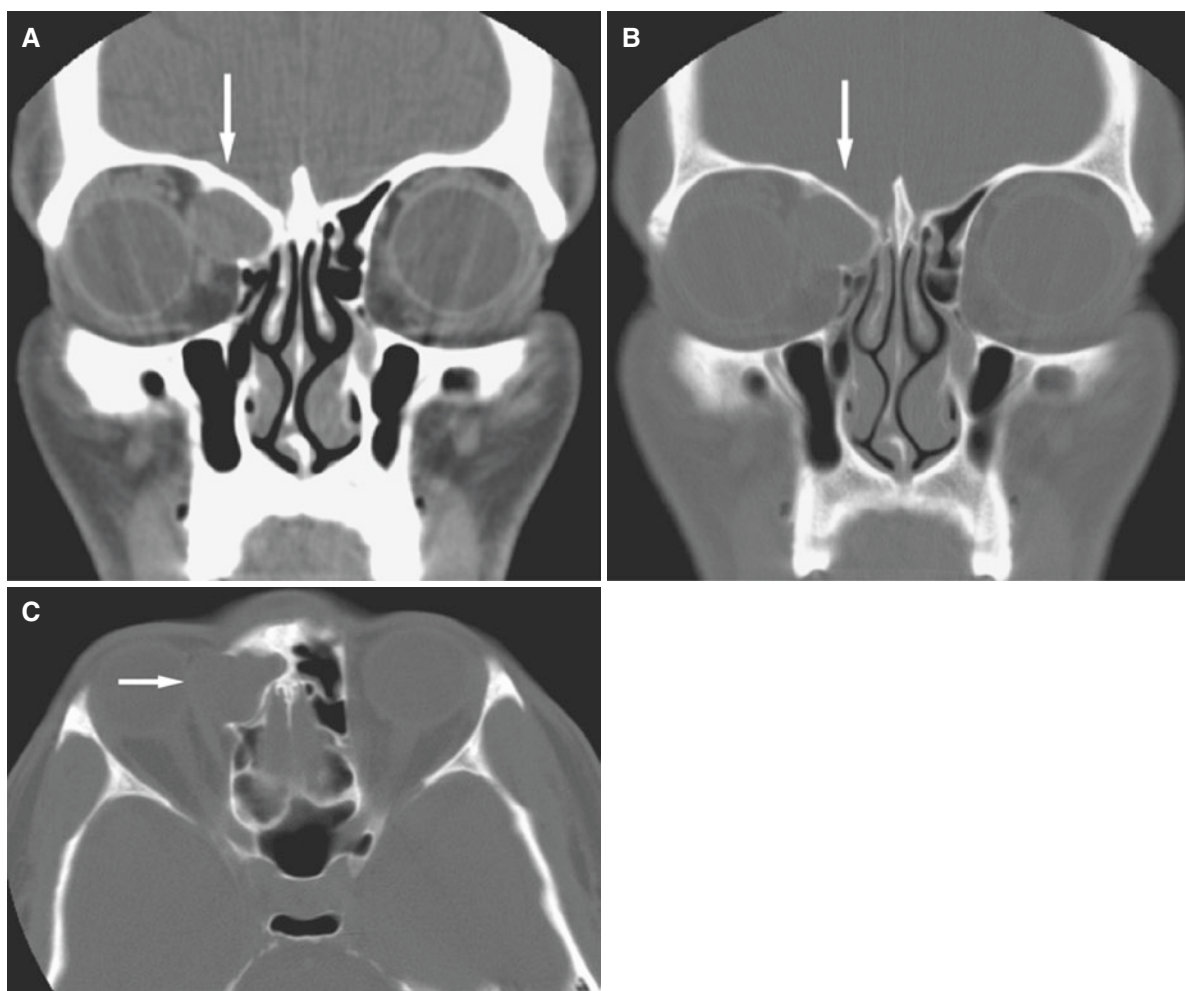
Frontal sinus mucocèle; 50-year-old male with diplopia and right eye down and laterally deviated. (A) Coronal CT image, soft-tissue window, shows ovoid well-defined soft-tissue mass in the right orbit (*arrow*) with displacement of globe laterally down. (B) Coronal
